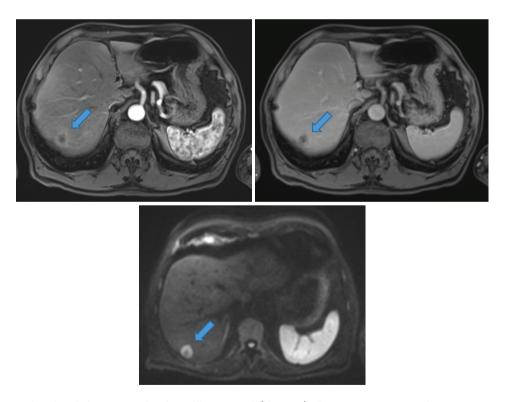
Typical appearance of a colorectal liver metastasis (blue arrow) in liver segment VIII on magnetic resonance imaging, with gadoxetic acid- rim enhancement on the early arterial phase (top left), washout on the delayed phase (top right), and high signal intensity on diffusion-weighted images (bottom)
